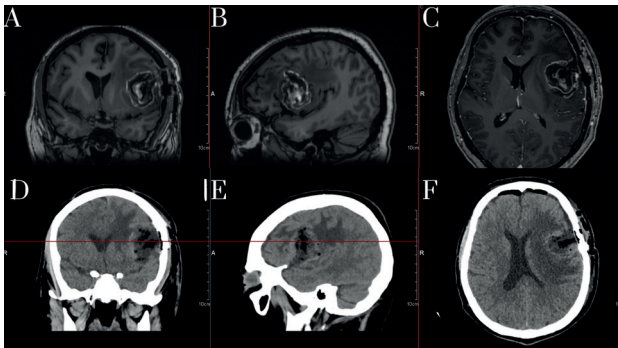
A, B, C: Postoperative MRI demonstrates the contents of the signal intensity corresponding to the cerebrospinal fluid, with foci of high density on T1WI along the periphery of the bed and along the course of operative access, due to hemorrhagic and hemostatic components. D, E, and F postoperative CT scan demonstrates no apparent complication.
